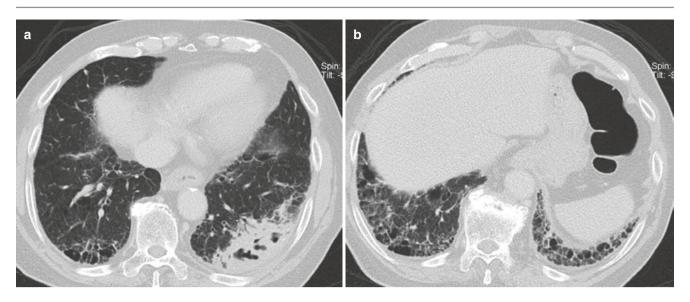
UIP with cavitary tuberculosis. (a, b) Axial CT images show "typical" UIP pattern with cavitary consolidation in a patient from tuberculosis-endemic zone
